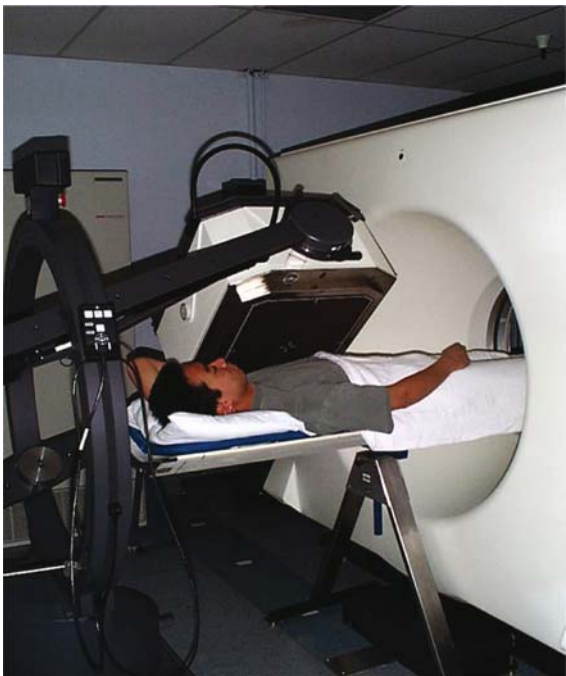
Combined SPECT/CT system configured at UCSF from a GE 9800 CT Quick CT scanner and a 400 XR/T SPECT system with a common patient table to translate the patient between the reconstruction volumes of the CT and SPECT systems. Reprinted with permission from ref.¹
